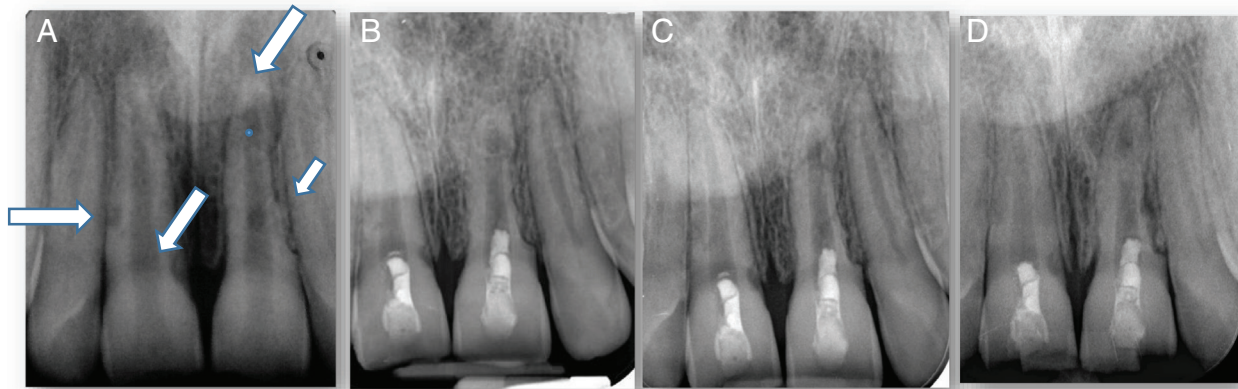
Case 1: teeth #8 and #9. (A) The preoperative periapical radiograph of teeth #8 and #9 showing ERR and a periradicular lesion in tooth #9 (arrows). (B) The periapical radiograph taken upon finishing PRF insertion. (C) The periapical radiograph taken 3 months postoperatively showing the reduction of periradicular radiolucency size and arrest of the resorption sites. (D) The periapical radiograph taken 30 months postoperatively showing a slight widening of the periodontal ligament in the coronal half of the distal aspect in tooth #9.
